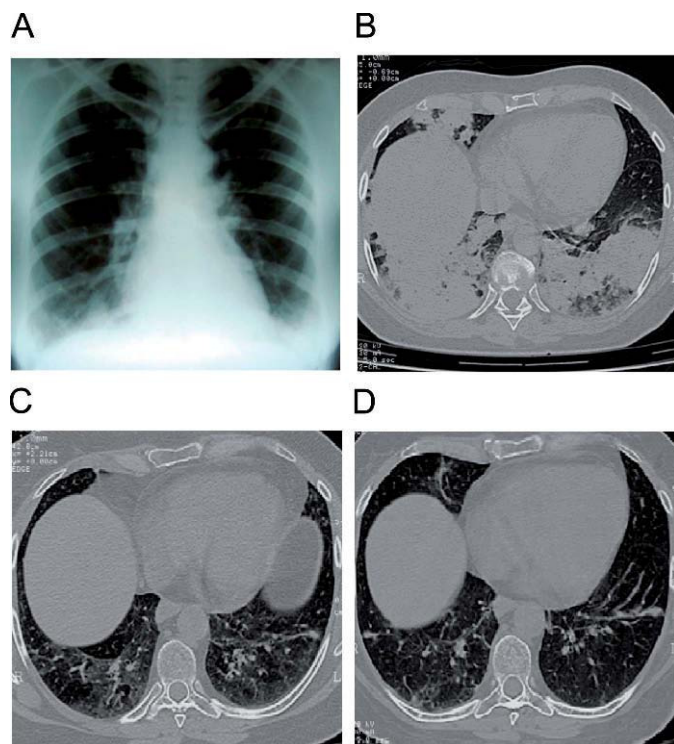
A) X-ray on admission. B) CT scan on admission. C) One month after treatment. D) 3 months after treatment.
